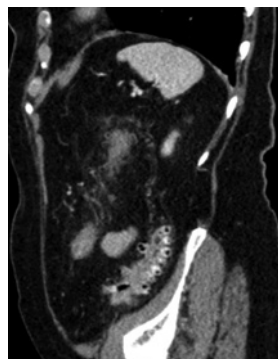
CT image of colon stenosis after chronic diverticulitis
